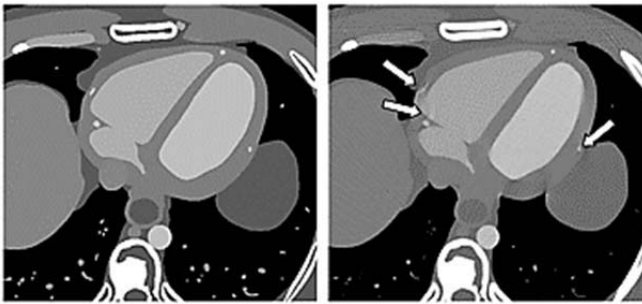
Sample noise-free transaxial-slice cardiac CT images at mid-diastolic phase with fast full scan (left) and at 333 ms/rotation short scan (right) showing the effect of motion of the coronary artery (arrows). Images were sharpened to show the artifacts more clearly.
